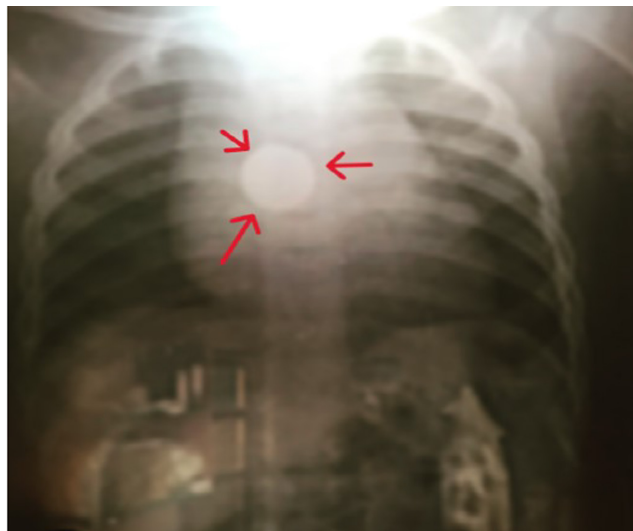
The patient's chest x-ray showed a round-shape foreign body in the middle of the thoracic esophagus. The diameter was measured to be 2.4 cm, and the thickness was 0.6 cm.
